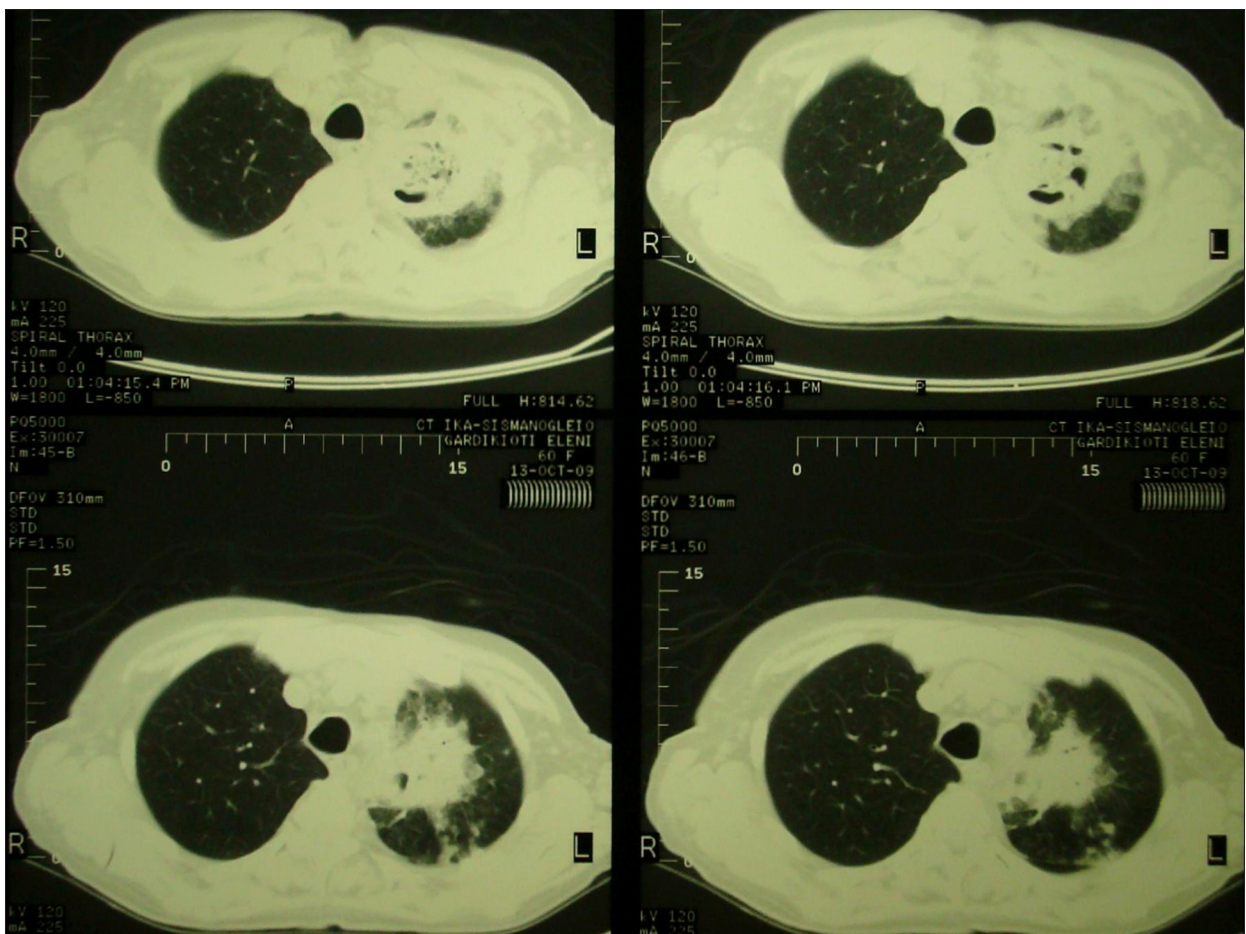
Chest CT scan showing a cavitating lesion in the left upper lobe.
